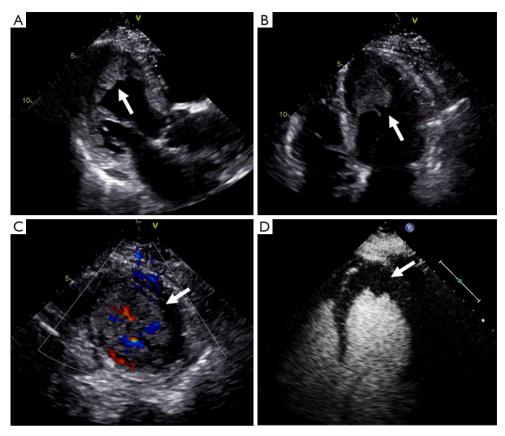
Two-dimensional echocardiography images. (A) Apical 3-chamber and (B) 4-chamber views show a thrombosis (arrows) extending from the left ventricular papillary muscle to the apex. Horizontal section of the short axis apex of the parasternal left ventricle (C) shows the left ventricle filled with thrombus, and color Doppler shows a small flow signal (arrow). (D) Contrast-enhanced ultrasound shows left ventricular thrombus without contrast microbubble development (arrow).
